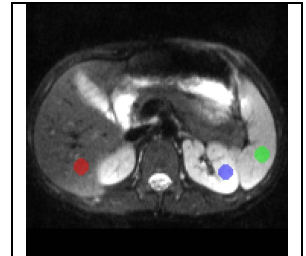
Representative example of the regions of interest used to analyze the fit quality overlaid on the DW-MRI image with b-value=5 s/mm^2
